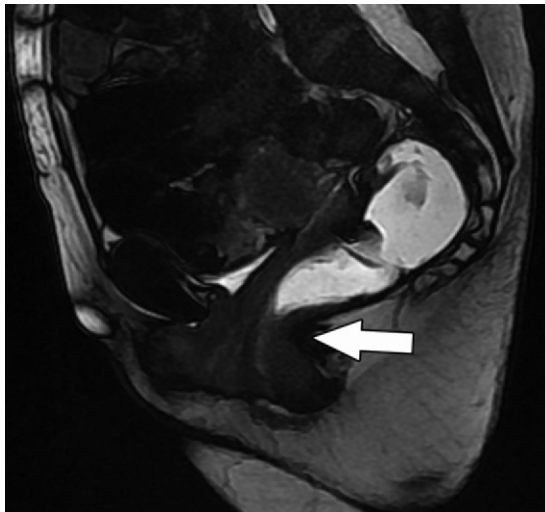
Anismus in a 29-year-old woman with suspected obstructed defecation. The patient was unable to defecate during the study. Midsagittal FIESTA MR image obtained at maximal effort to defecate shows lack of descent of the pelvic floor, a prominent puborectal impression (arrow), and failure of the anorectal angle to open.
